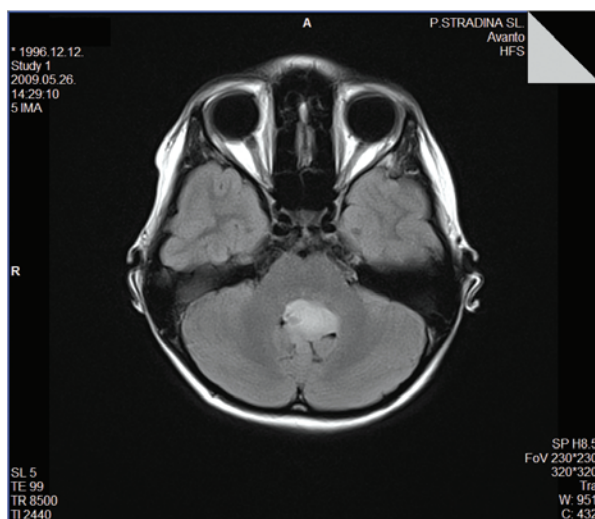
MRI scan before the operation. Tumour of the 4th ventricle. Note the contrast enhancement of tumour
